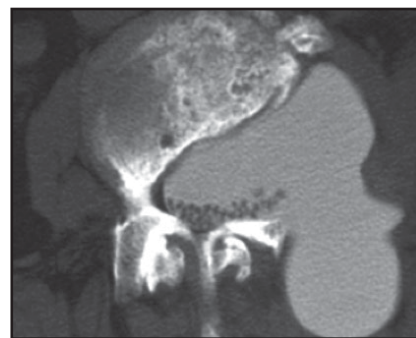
Lateral thoracic meningocele. Axial image from a CT myelogram demonstrates a large meningocele extending through and expanding the left neural foramen and into the adjacent paraspinal soft tissues. Image courtesy of Paul M. Sherman, M.D.
